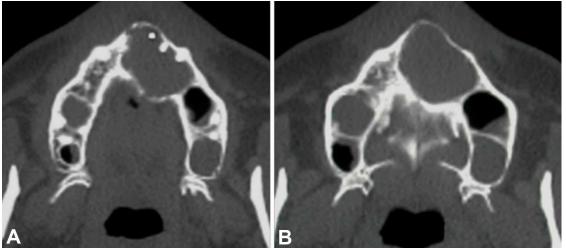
A and B. Axial CT where showing expansion in the vestibular and palatal cortical bone. Incidentally, thickening of the mucosa of both maxillary sinuses is also observed.
